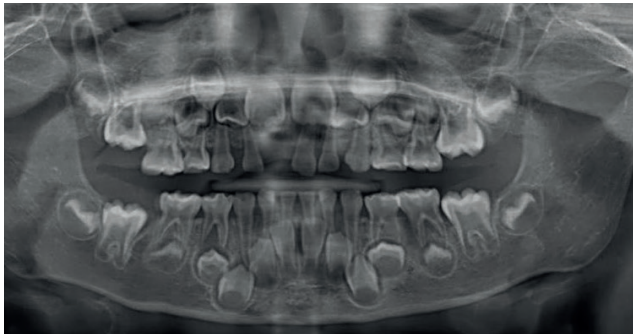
Orthopantomogram shows abnormal dental morphology with large pulp chambers in all deciduous teeth as well as in the first permanent molars. The sequence of tooth eruption and formation is compatible with the patient's chronological age.
